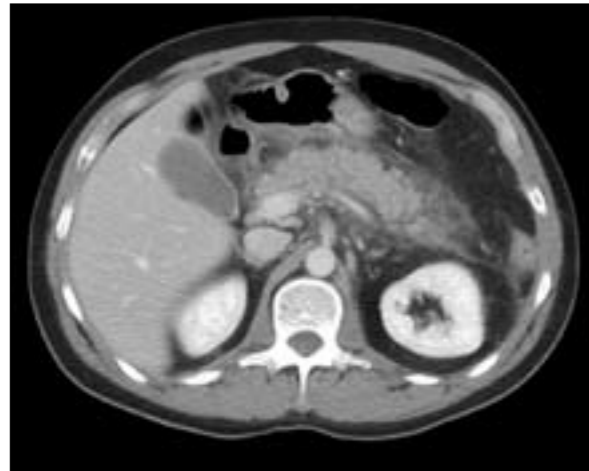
Computed tomogram of acute pancreatitis showing pancreatic swelling as a result of oedema plus inflammation in the surrounding tissues.
